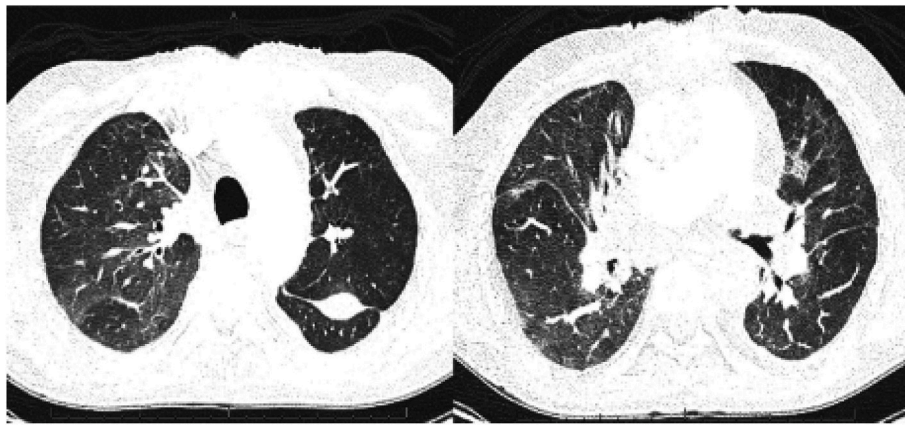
Representative high-resolution axial CT lung window images through the upper and lower lobes on the 50 days status post-transplant. It demonstrates ground glass opacities and interlobular septa and fissure thickening, suggestive of pulmonary edema.
